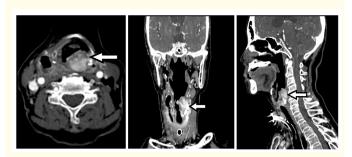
Axial, coronal and sagittal view of head and neck CT imaging revealed a lesion (white arrow) at left laryngeal region from the level of C4 to C7 with narrowed airway at this region. The mass is continuous with the left upper pole of thyroid.
